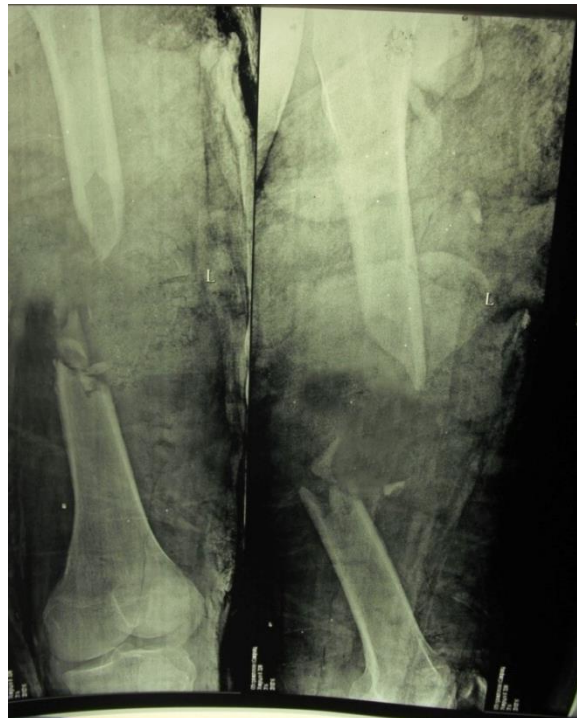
1.13.07.2015y. Patient was born in 1983. diagnostic radiograph of the left femur.
